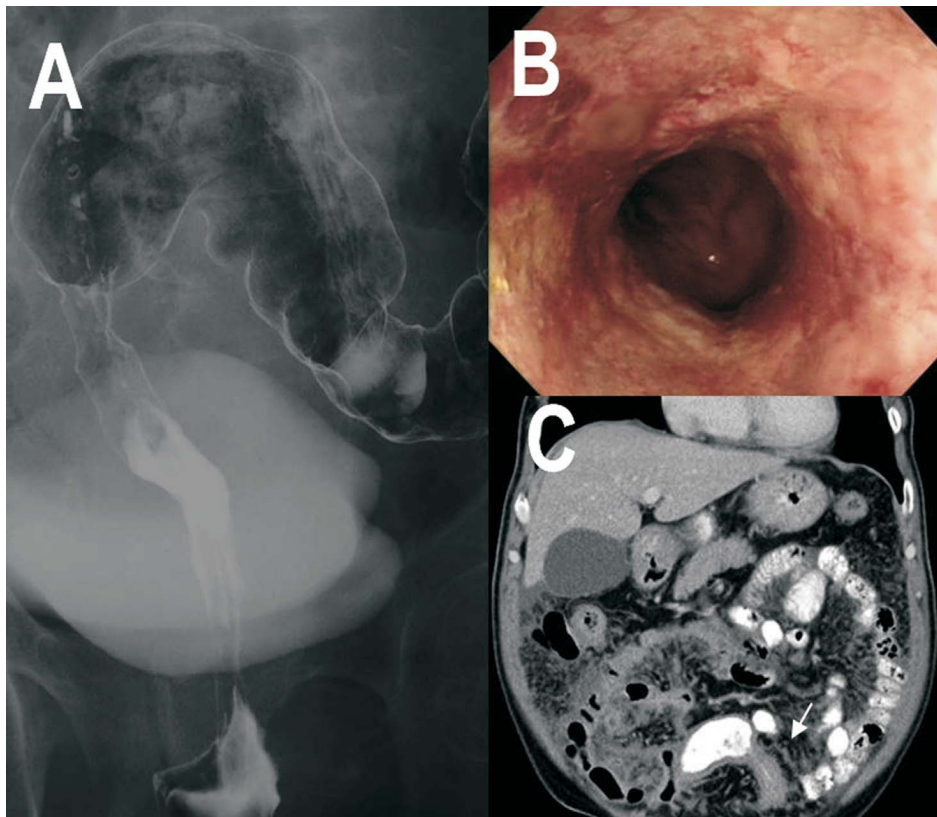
A 64-year-old man with UC for more than 10 years had constipation. Double colon series showed stricture in the rectosigmoid (A). Repeated biopsy from the stricture area showed only dysplasia (B). Computed tomography revealed peritoneal carcinomatosis (C).
